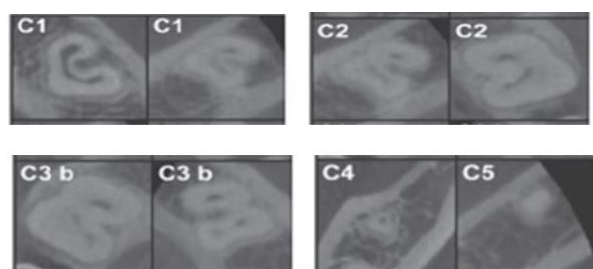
Cross-sectional CBCT images of different types of C-shaped canal configurations, at different root levels.
